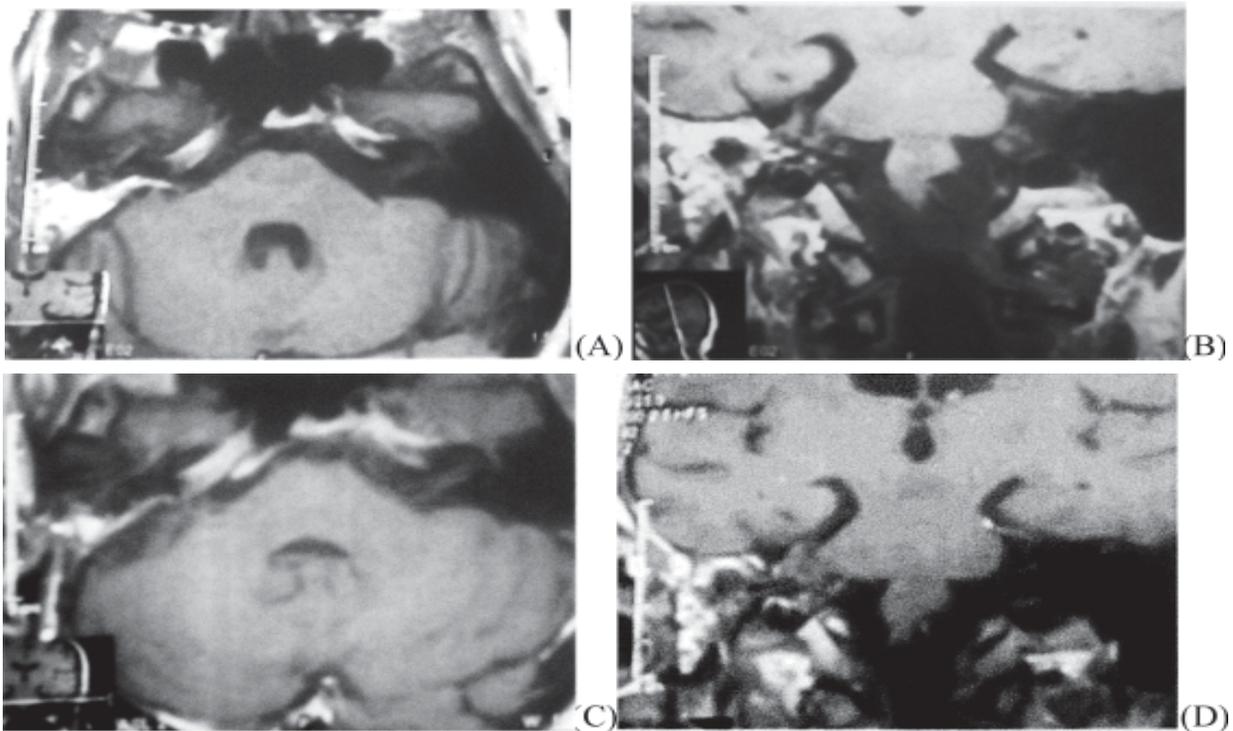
Follow up MRI in 2002 (A: axial, B: coronal) shows no evidence of residual or recurrence of tumor after ETLA, B: Follow up MRI in 2004 (C: axial, D: coronal) also shows no evidence of recurrence of tumor.
